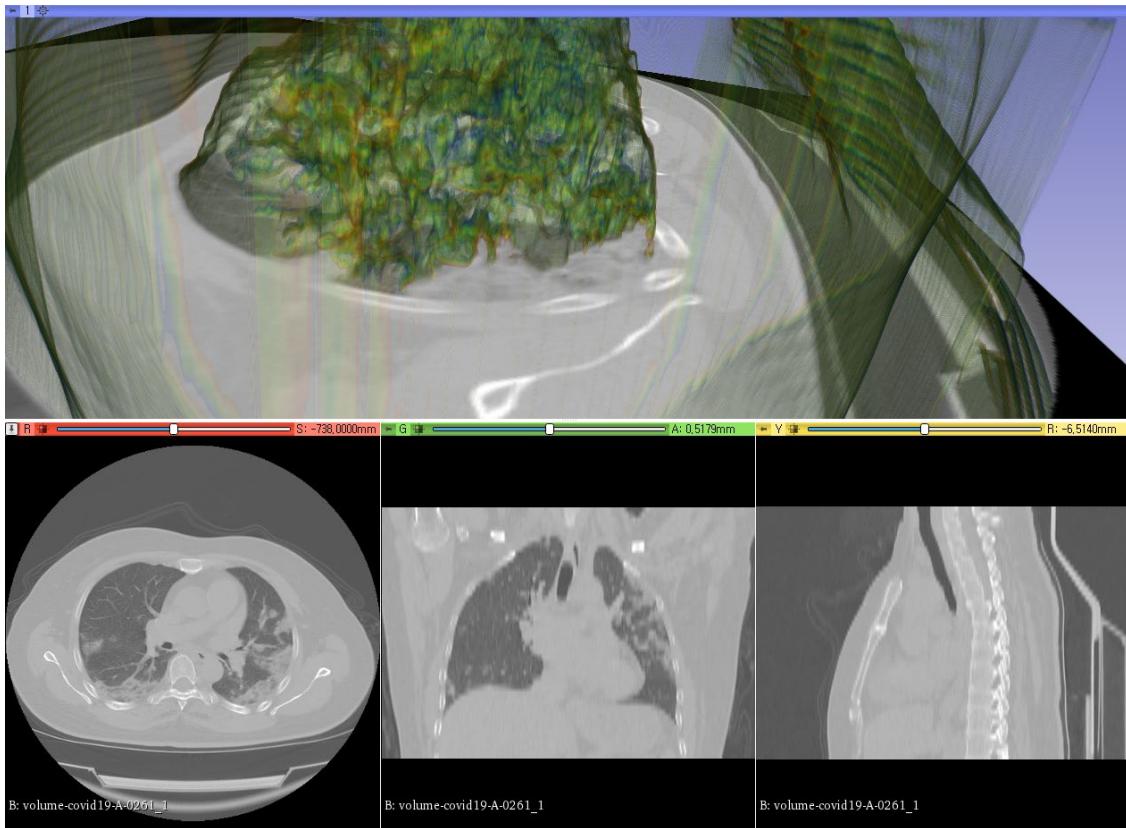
COVID Patient 261 Lung CT Scan: 2D and 3D Rendering Using 3D Slicer
